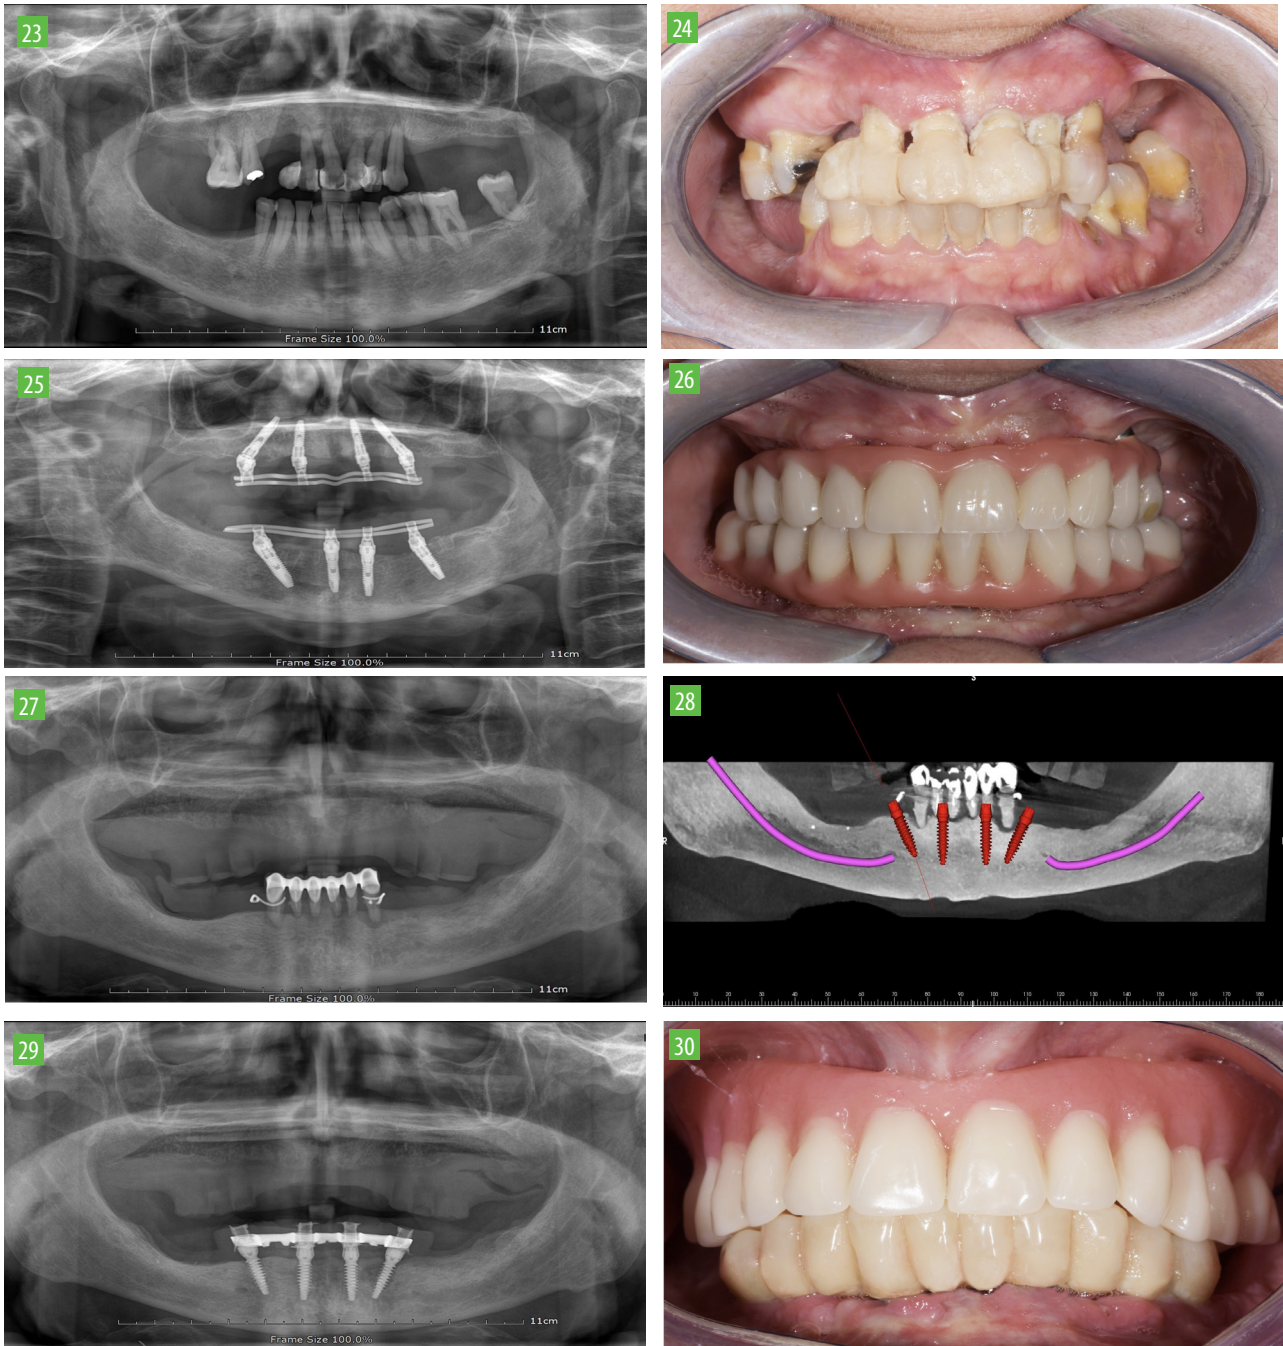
Pre op x-ray. 78 years old woman clinical case.
